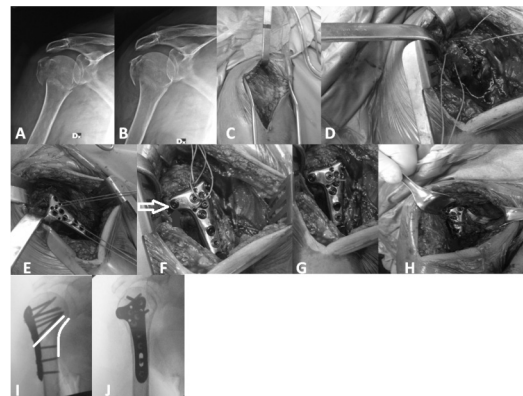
A, B) Three parts fracture of right proximal humerus, 36-year-old male, fallen from height, C) deltopectoral approach, D) non-absorbable suture wires through greater tuberosity, E) placement of wires and plate, F) placement of plate and screws, F) screw that directly stabilizes the large tuberosity (white arrow), G) nodding closure and non-absorbable wires, H) view of the synthesis before closure, I, J) post-op radiographs show good reduction of the medial wall (I, curved white line) green and the importance of the kickstand screw (I, straight white line) (Rollo G,2016).
